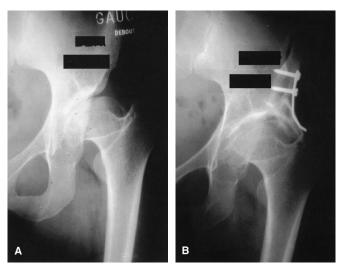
A, Preoperative AP radiograph of a 24-year-old woman shows a slight dysplasia (center edge angle, 4°), no loss of congruency but a loss of the femoral head sphericity, and an acetabular roof condensation without joint space narrowing (arthrosis Grade 2). The patient had a congenital hip dislocation for which she was treated conservatively during childhood. B, Anteroposterior radiograph taken 20 years after shelf arthroplasty shows no evidence of arthrosis progression; the bone density of the graft was satisfactory. The Merle d'Aubigné hip rating increased from 15 points preoperative to 18 points at the last followup.
